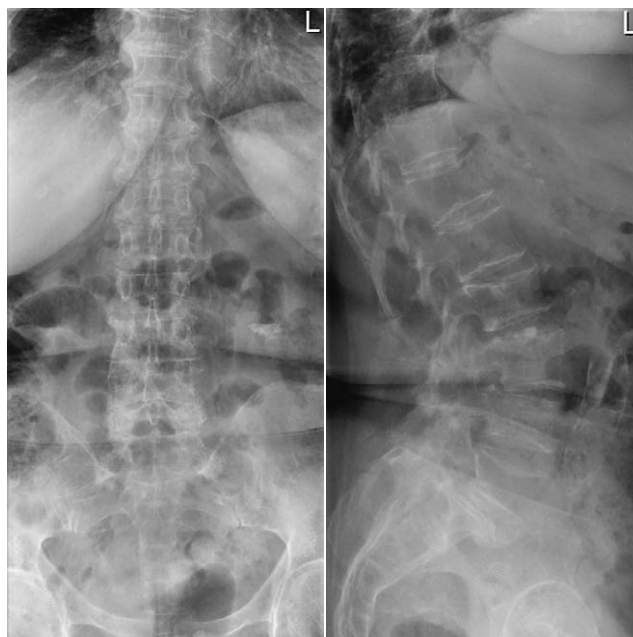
Radiographs of the LS spine showed vertebral compression fracture of the second lumbar vertebra (L2) (grade II according to the Genant classification of vertebral fractures) with diffuse degenerative changes, hypertrophic osteoarthropathy of intervertebral joints at the L3–S1 level, and signs of skeletal osteopenia.
